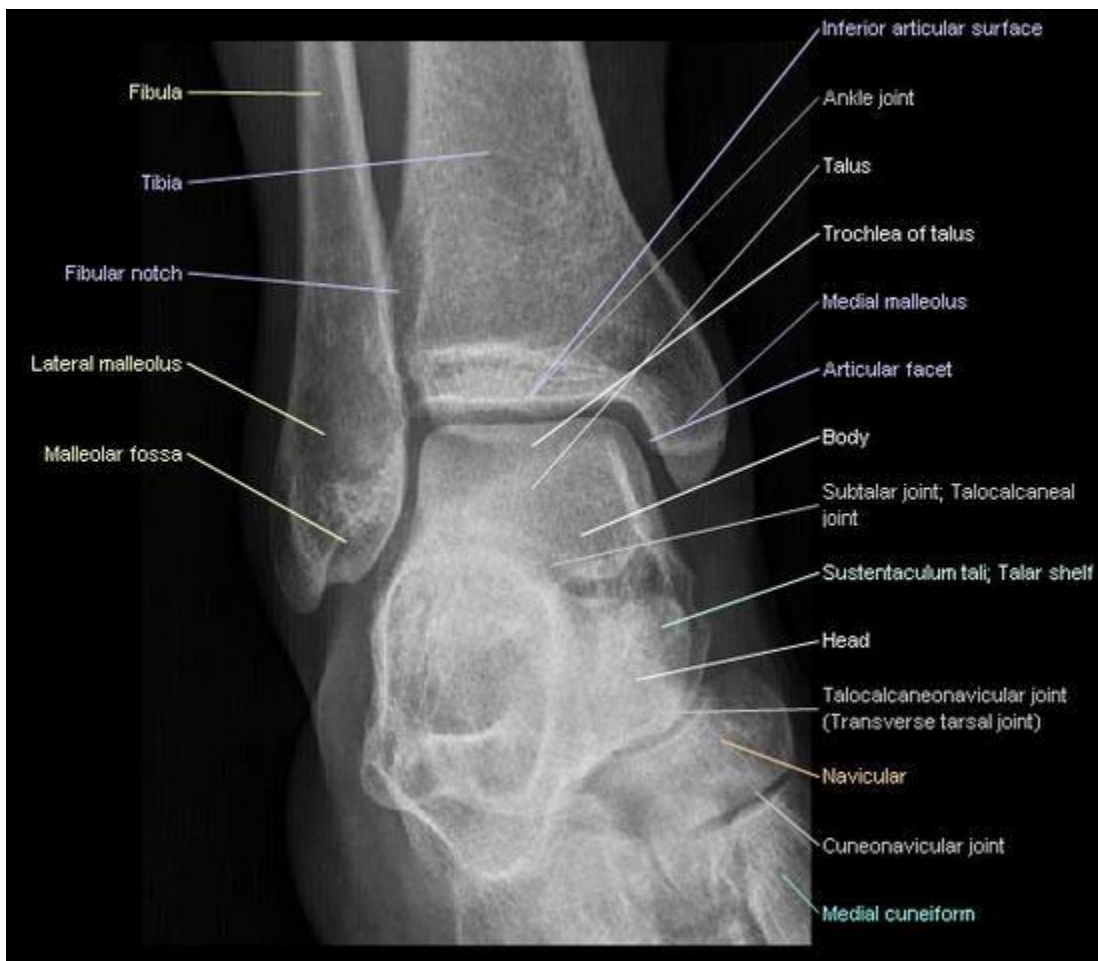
Radiographic antero-posterior view of the ankle joint. (www.e-radiography.net, 2012)
